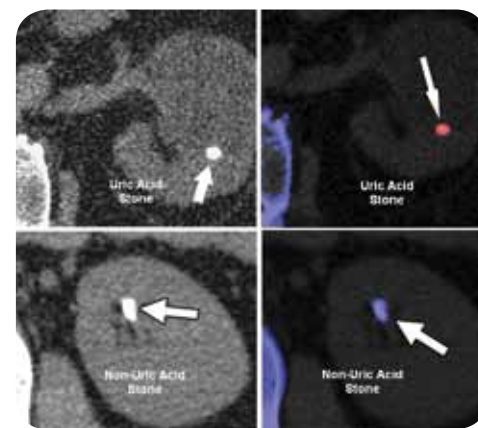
Dual-energy CT can reliably distinguish uric acid (coded red) from calcium-containing (coded blue) stones based on tissue attenuation characteristics.
